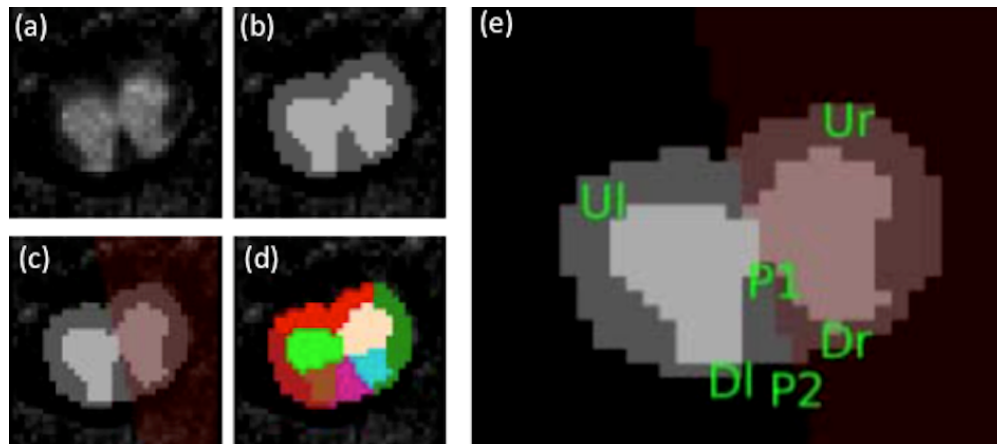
(a) DWI, (b) WM/GM segmentation, (c) Left/Right axis, (d) final segmentation into dorsal, lateral and ventral WM, as well as ventral and dorsal GM. (e) Points used to define the substructure of the WM and GM tissues. From (Sdika et al., 2010), with permission from the authors.
